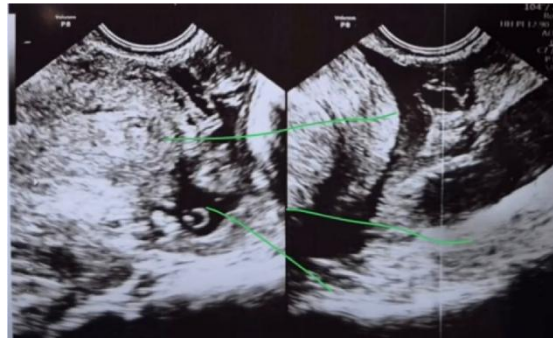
Ultrasound of pregnancy on the rest of the right fallopian tube
